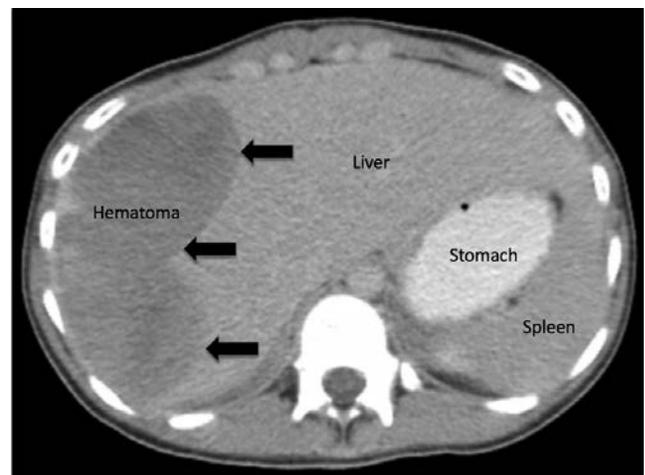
Abdomen computed tomography with contrast demonstrating Grade III liver injury. Note: Right subcapsular parenchymal hematoma approaching 50% of surface area without extravasation.
